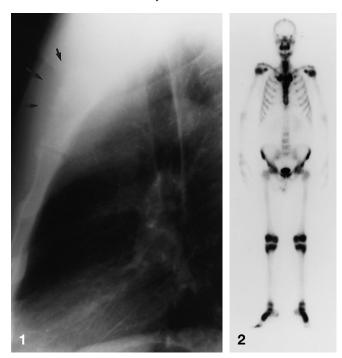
Plain radiograph shows a lytic mass in the sternum (*arrows*). Note the spiculated anterior border of the lesion
